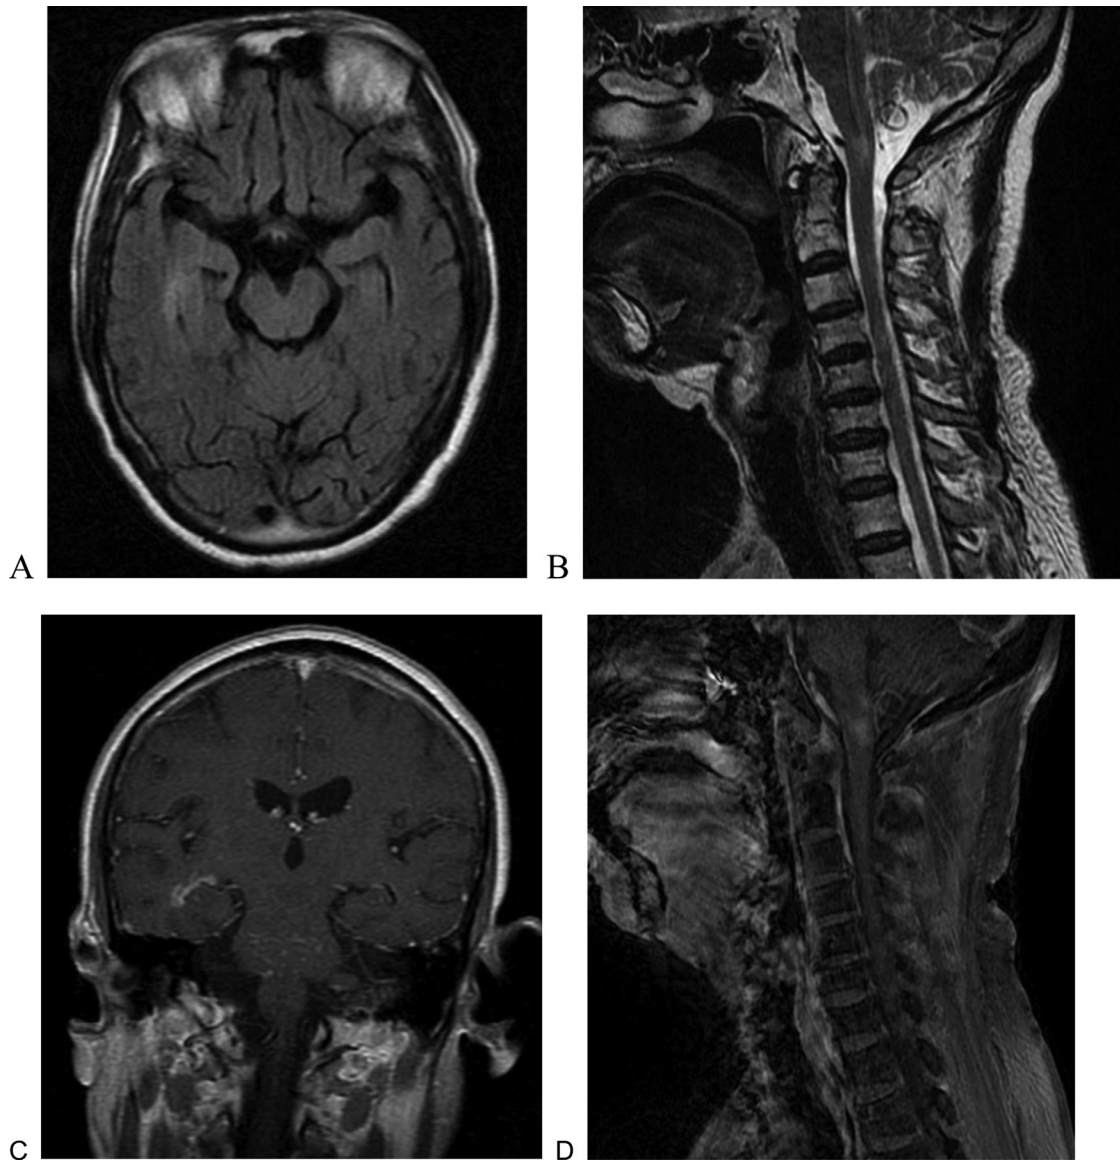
(A-D) Brain and Neck MRI.
